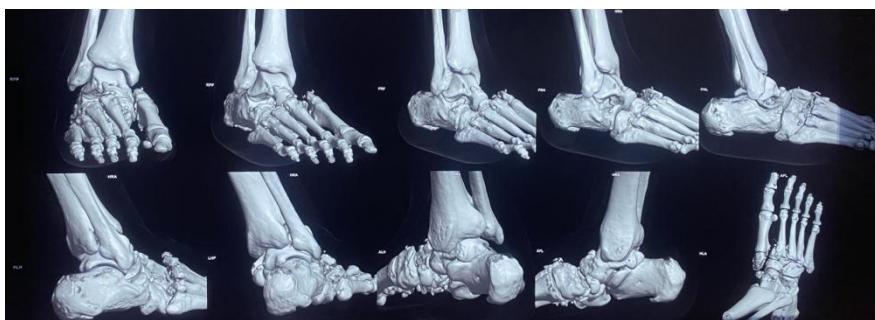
Preoperative CT scan (axial view) demonstrating malalignment and fragmentation involving the central and lateral columns of the midfoot.
